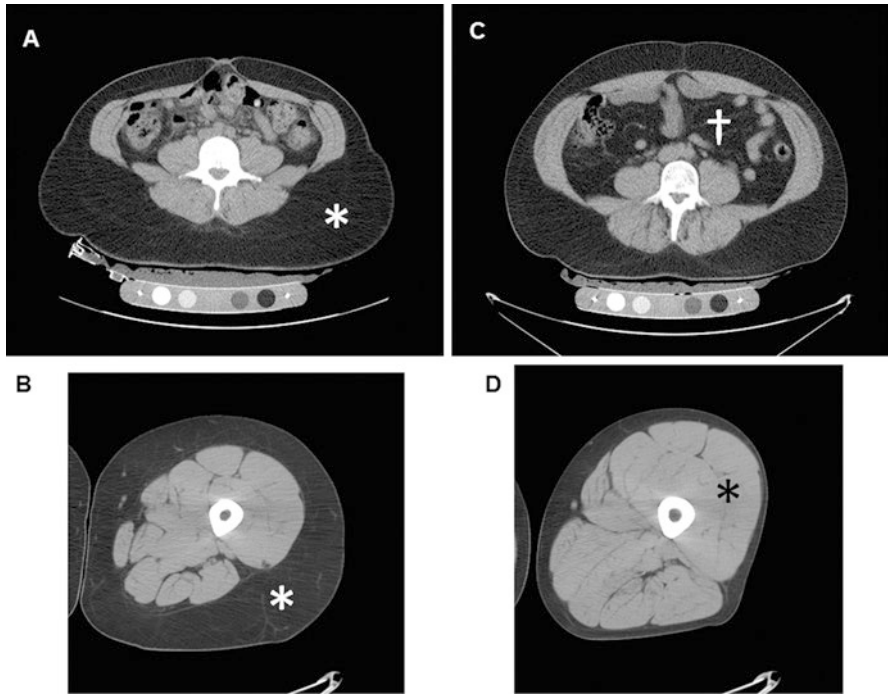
Body composition of the abdomen and thigh assessed by CT in a 39-year-old woman (a, b) and 37-year-old man (c, d) with obesity (BMI, 33 kg/m²) who were otherwise healthy. The woman has more subcutaneous adipose tissue in the abdomen and thigh (*white asterisks*), while the man has more visceral adipose tissue (*cross*) and muscle mass (*black asterisk*). The woman had a better metabolic profile compared to the man (serum LDL cholesterol 57 mg/dL vs 147 mg/dL; HDL cholesterol 68 mg/dL vs 32 mg/dL; triglycerides 45 mg/dL vs 159 mg/dL; insulin 4.9 μU/mL vs 7.0 μU/mL; HOMA-IR 0.98 vs 7.00)
